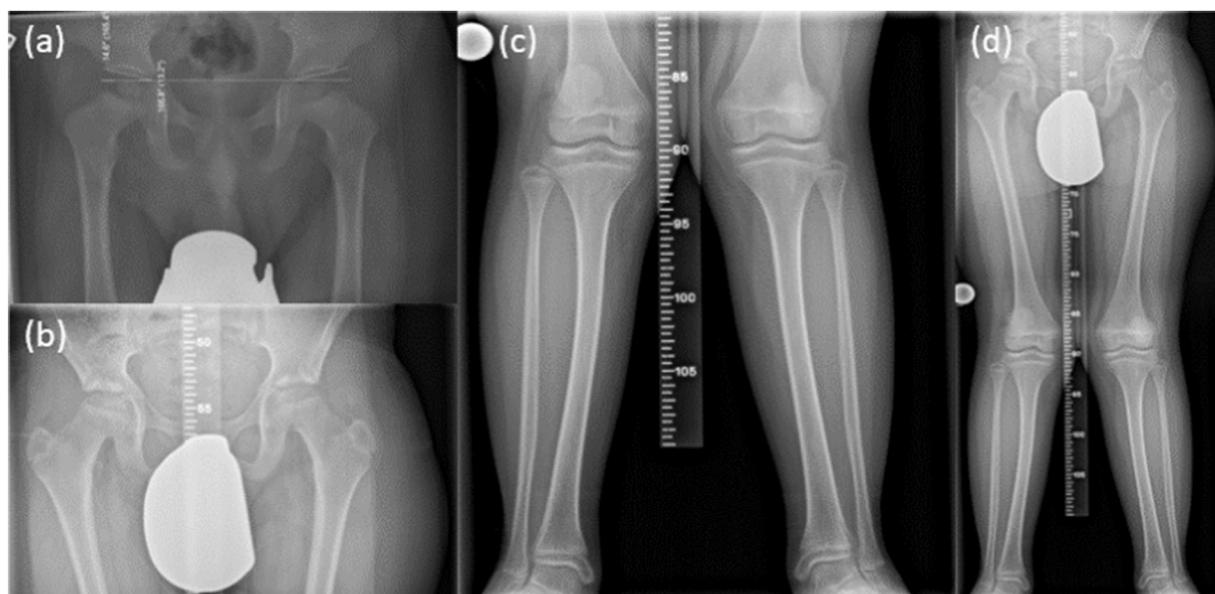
Radiographs of the pelvis (a), hips (b), knees and lower legs (c) as well as whole legs (d).
